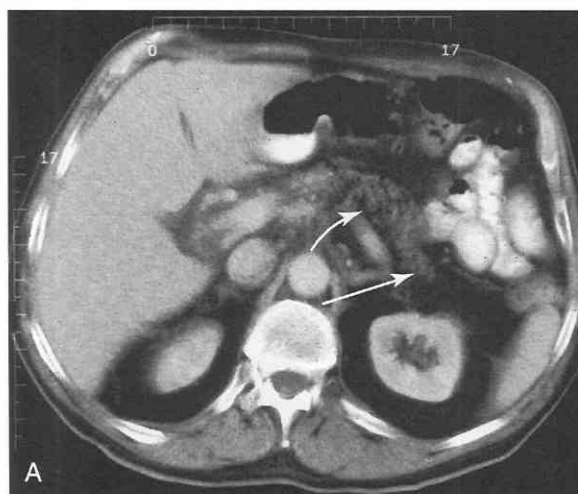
A, CT scan shows low density with atrophy of two portions of the pancreas (*arrows*). B, Chronic inflammation may result in complete atrophy of the glandular elements so that the only residual is a faint pattern of the ductal system (*arrow*).
